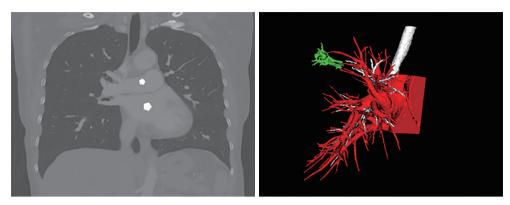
A preoperative 3D reconstruction of the right pulmonary anatomic structure deemed unsatisfactory due to the poor quality of the enhanced CT scan. 3D, three-dimensional.
